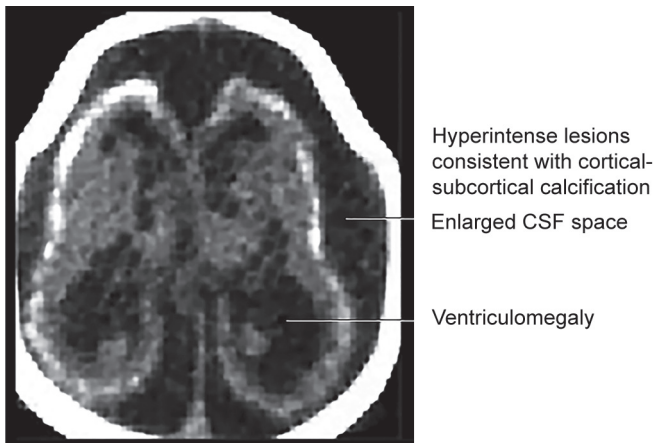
Axial CT image of an infant with congenital ZIKV infection and severe microcephaly shows cerebral atrophy with ventriculomegaly, prominent cerebrospinal fluid space, and extensive, punctate cortico-subcortical calcifications.
